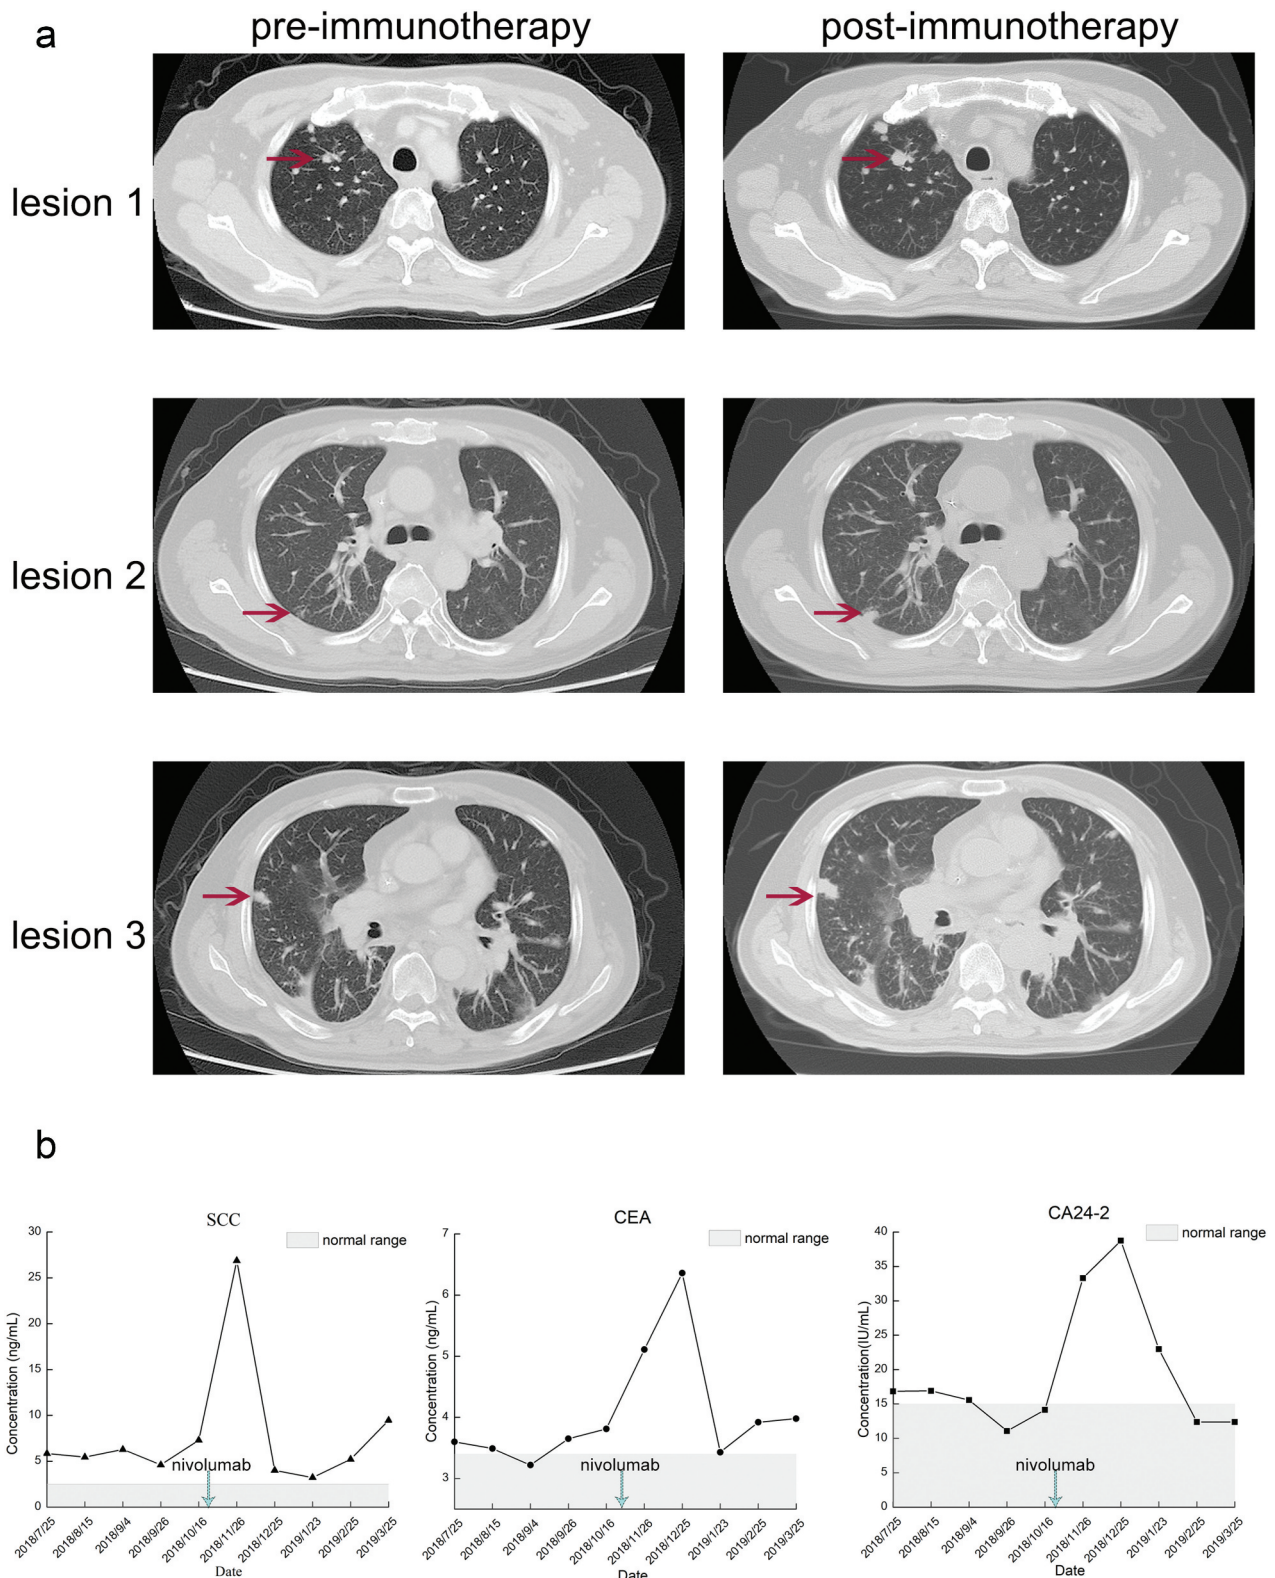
CT scan and tumor markers of the patient experienced HPD after nivolumab treatment. (a) The CT scan before and after nivolumab treatment. In this case, HPD was defined as a disease condition after anti-PD1/PD-L1 treatment which has a short TTF (less than 1 month) and a more than 50% increase than baseline in the size of the lesion. (b) The alterations in tumor markers during nivolumab treatment.
